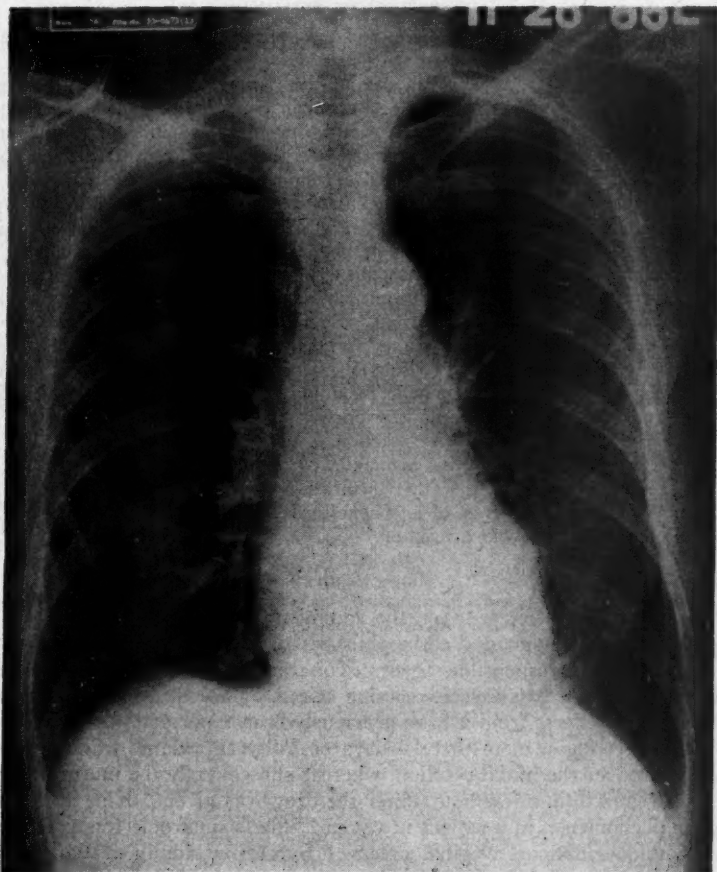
Roentgenographic appearance of the chest three months after Löffler's syndrome. Lung fields are clear.
